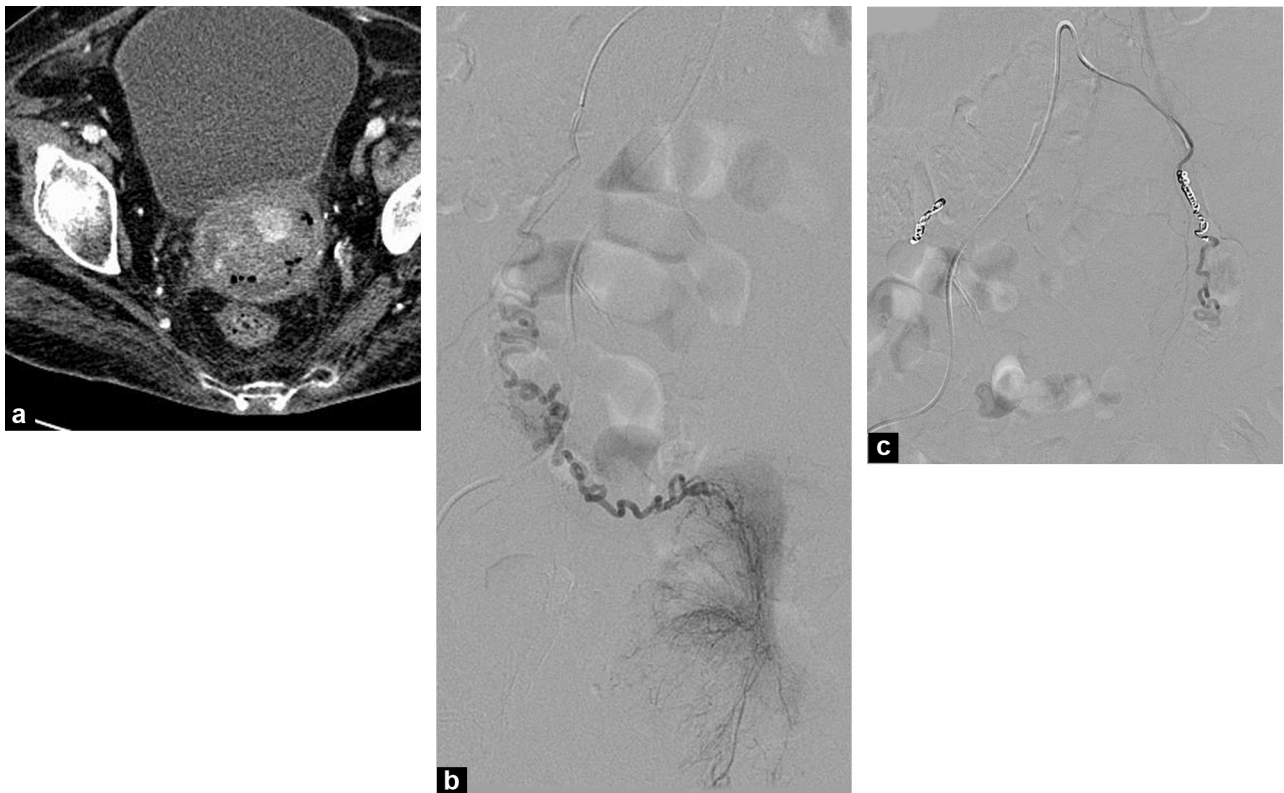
Irretractable metrorrhagia due to cervical cancer: a: CT after enhancement. Hypovascularized infiltrating mass next to the cervix; b: tumor enhancement during selective catheterization of the left uterine artery; c: devascularization of the tumor after embolization (non-resorbable particles and coils).
